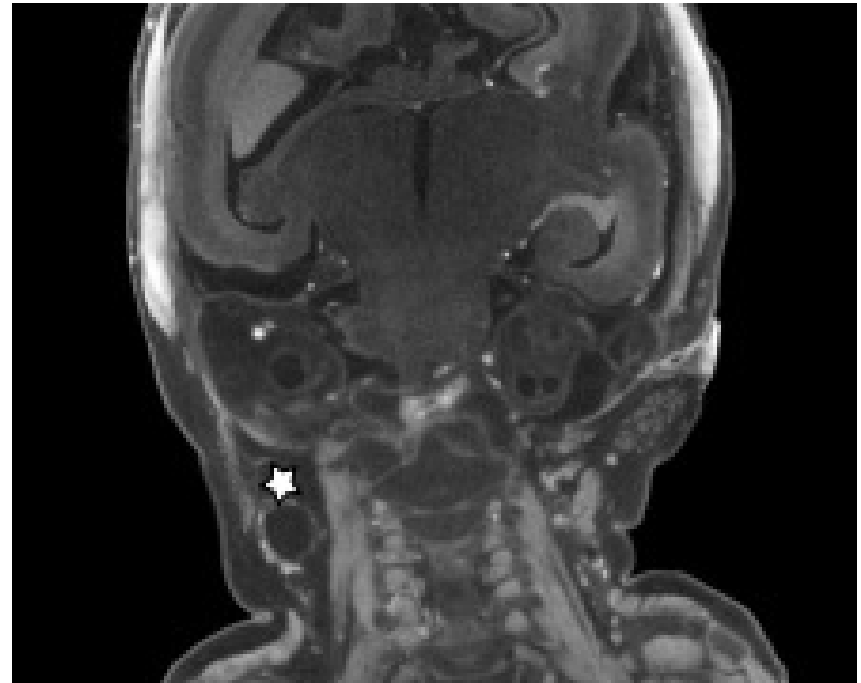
An apparent overcall from micro CT data in case 5 was a cystic neck lesion (star), which was overlooked at autopsy, as this region is not routinely dissected.
